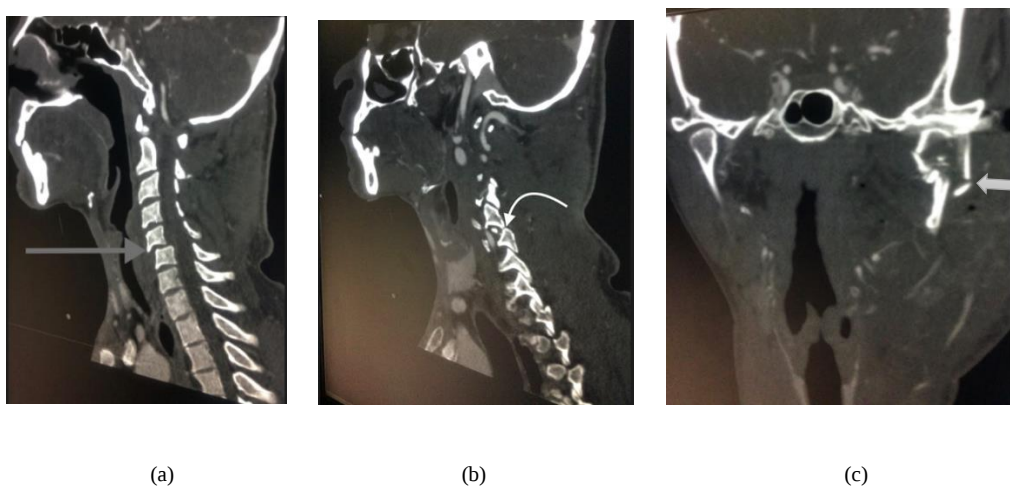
Sagittal views of bone windows of the CT scan of the neck
